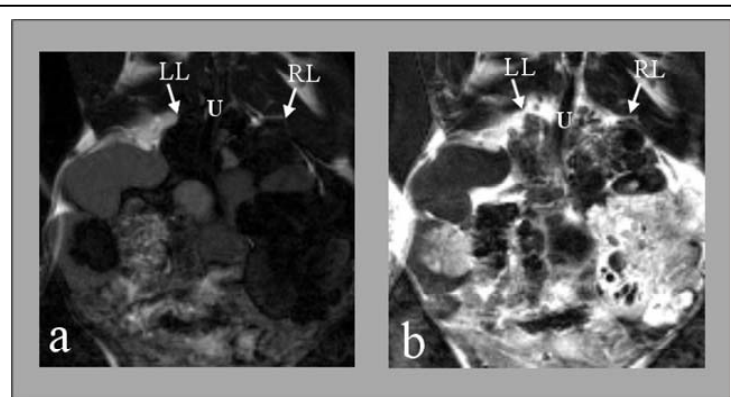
Inversion recovery MRI images acquired with $T_I=800\text{ms}$ are shown during pre-contrast control (a), and following Gd(ABE-DTTA) administration (b). LL, RL indicate left and right lobe of the prostate, respectively and U labels the urethra.
